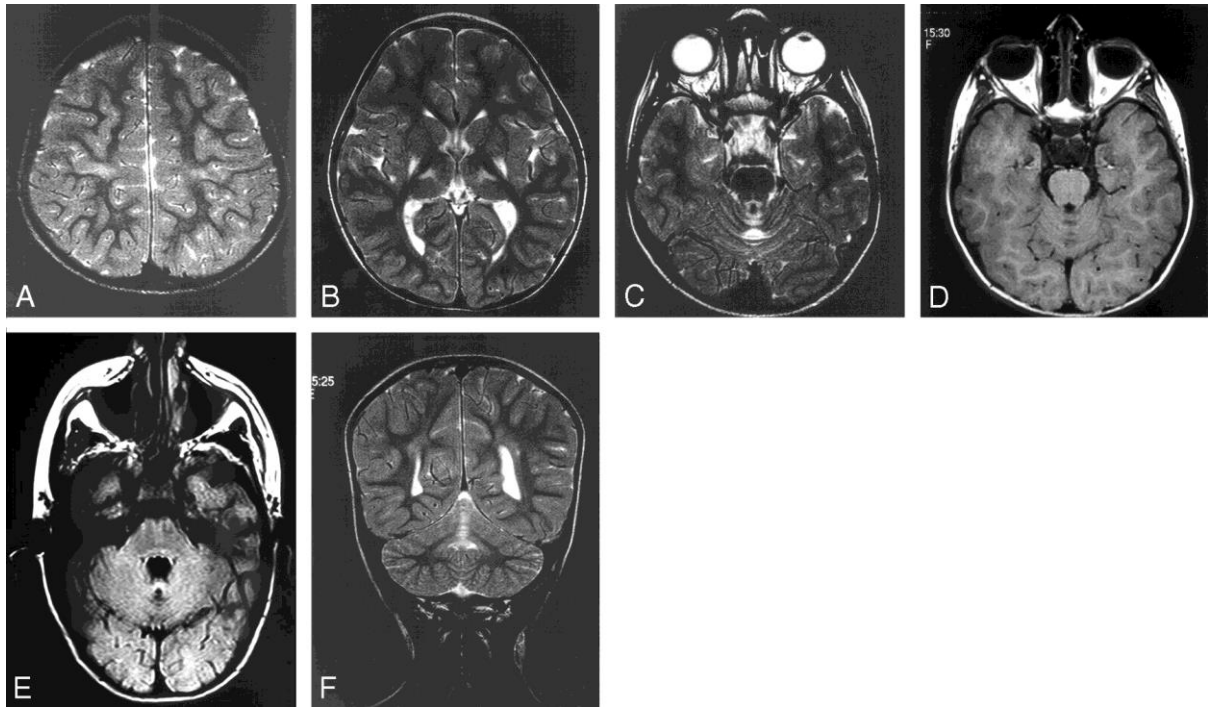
Five y.o. girl with athetoid spastic quadriplegia. a) Axial T2. Mild signal change in the perirolandic white matter. b) Axial T2. Typical signal change in the posterior putamen and the ventrolateral thalamus bilaterally. c) Axial T2. Typical signal change in the anterior lobe of the vermis. d) Axial T1. Low T1 signal change in the vermis. e) Axial FLAIR. High T2 signal and cystic change. f) Coronal T2. Anterior lobe of vermis high T2 signal change.
